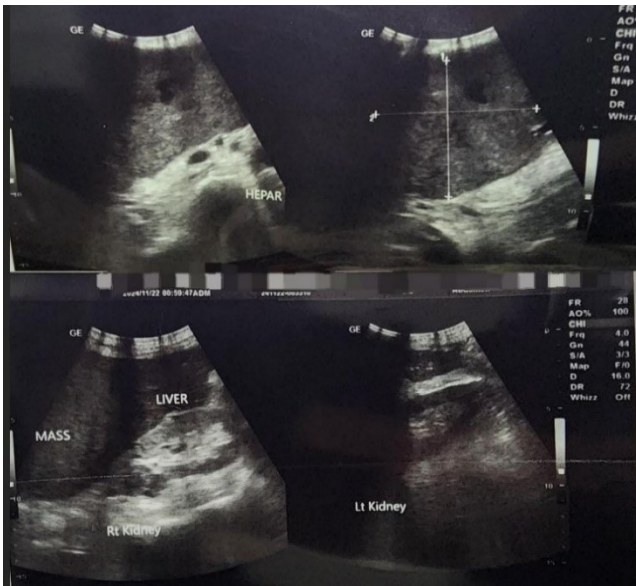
Abdominal ultrasound shows a large, lobulated mass measuring 8.3 × 8.7 cm with heterogeneous internal echogenicity in the right liver lobe. The liver parenchyma appears inhomogeneous. These findings suggest a large right lobe liver mass, supporting the diagnosis of hepatocellular carcinoma (HCC) with possible underlying chronic liver disease
